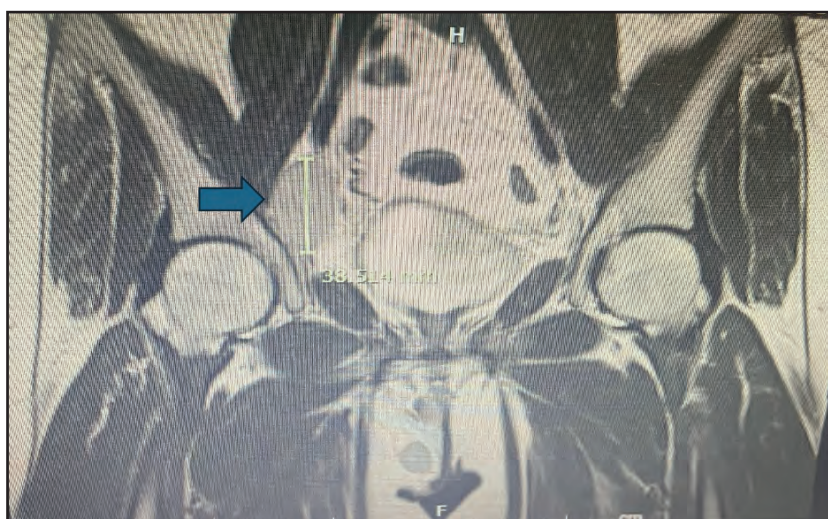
MRI of pelvis showing enlarged right external iliac lymph nodes
